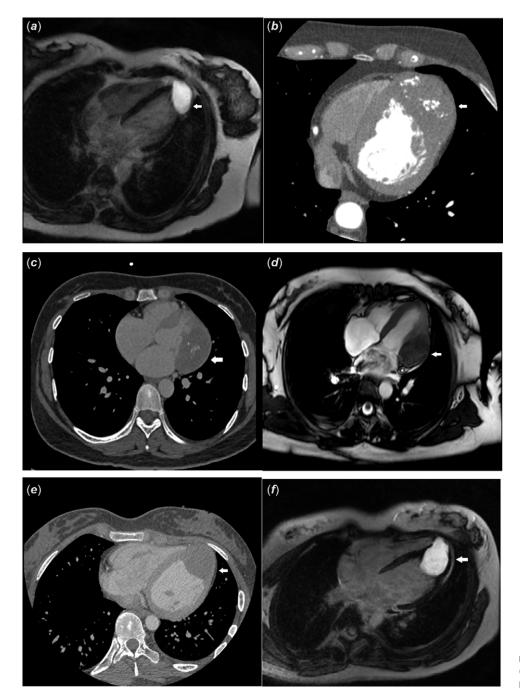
(*a*) MRI of patient 1. (*b*) CT of patient 2. (*c*) CT of patient 3. (*d*) MRI of patient 3. (*e*) CT of patient 4. (*f*) MRI of patient 4.
